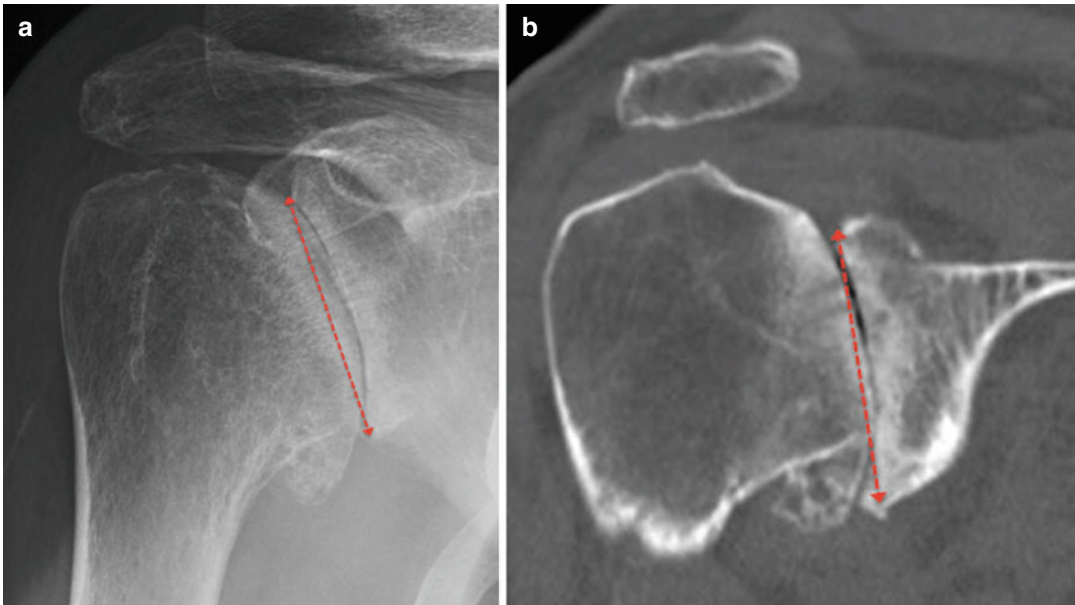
Glenoid height* – the *double arrows* are intended to outline the measurement of glenoid height on a AP radiograph (a) and CT coronal reconstruction (b). The
